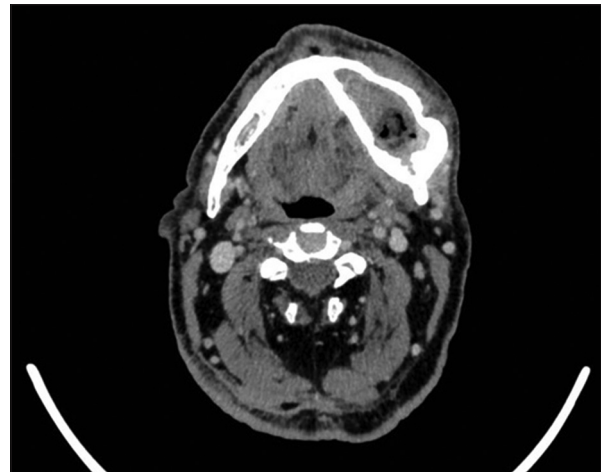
Axial computed tomography image of mandibular intraosseous odontogenic squamous cell carcinoma. The lesion affects the body and the ascendant branch of the mandible in the left side
